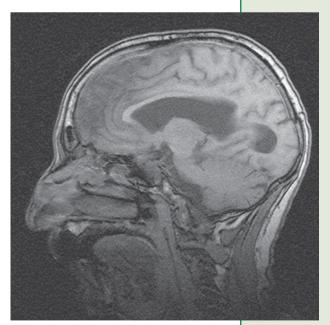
(b) MRI of the brain showing a loss of differentiation between the grey matter and the white matter; this may be due to a lack of blood supply to the brain—a stroke
